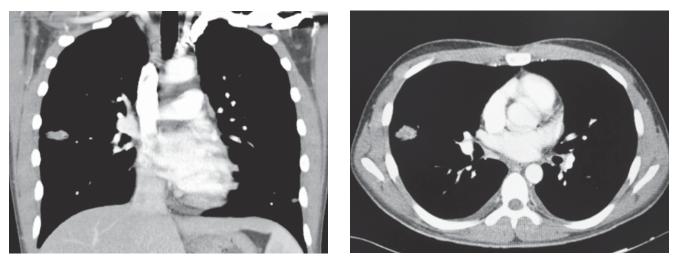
Computed tomography (CT) images of multiple, variable-sized nodules with ground-glass halo in the lung (images obtained three days after admission).
